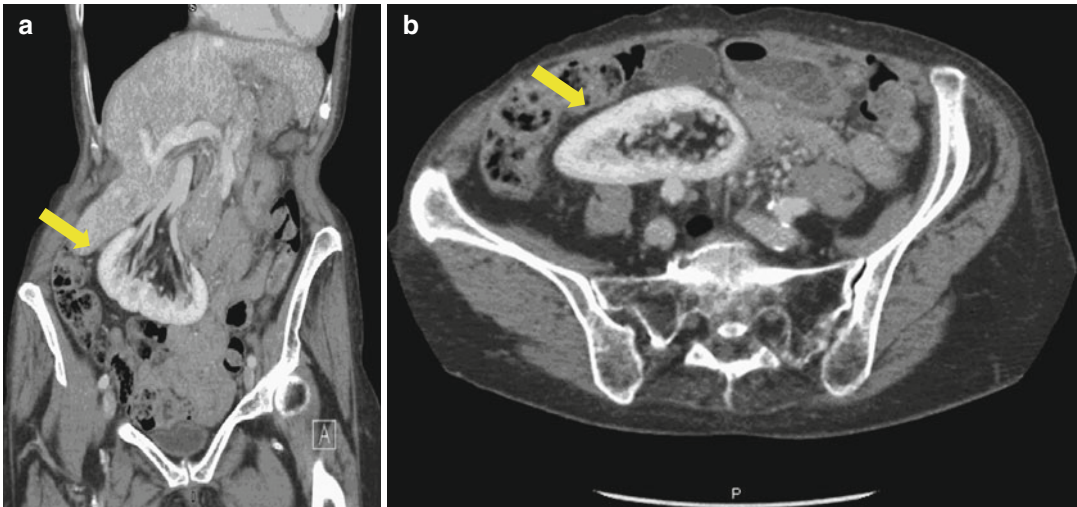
Coronal (a) and (b) axial (b) CT scan images demonstrating a malrotated pelvic kidney (yellow arrow)
